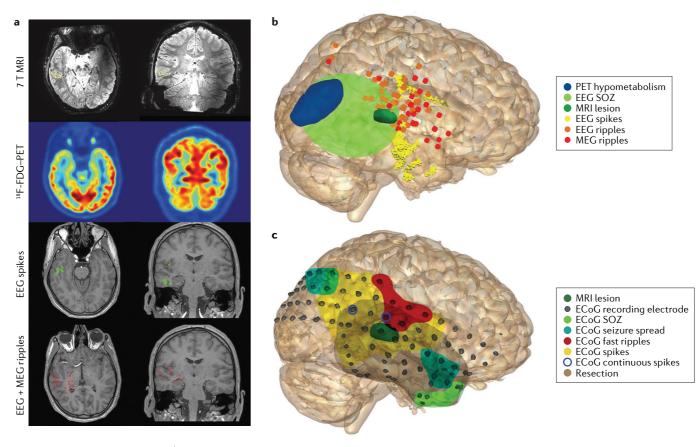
Multimodal imaging. The figure shows data from a patient with focal epilepsy who experienced bilateral tonicclonic seizures preceded by dizziness as the presenting semiology. a | Transverse and coronal image slices from 7 T MRI and ¹⁸F-fluorodeoxyglucose PET (¹⁸F-FDG–PET), along with projected EEG localized spikes and magnetoencephalography (MEG) + EEG ripples. b | Data from noninvasive techniques projected onto a 'glass brain'. The image depicts PET (dark blue), ictal EEG (light green), MRI (dark green), interictal EEG (yellow) and interictal ripples (orange for EEG and red for MEG). c | Invasive and intraoperative findings projected onto a 'glass brain'. The image shows the resected area (grey), the MRI lesion (dark green), the electrocorticography (ECoG) seizure onset zone (SOZ; light green) and seizure spread (turquoise), fast ripples (red), interictal spikes (yellow) and sites of continuous spiking (encircled with dark blue). The MRI findings show a close relationship with the fast ripples, continuous spiking pattern and EEG and MEG ripples. The irritative zone, SOZ and PET hypometabolism extend beyond the resection margin. After resective surgery, the patient received antiepileptic drugs and was seizure-free after a follow-up period of 24 months.
